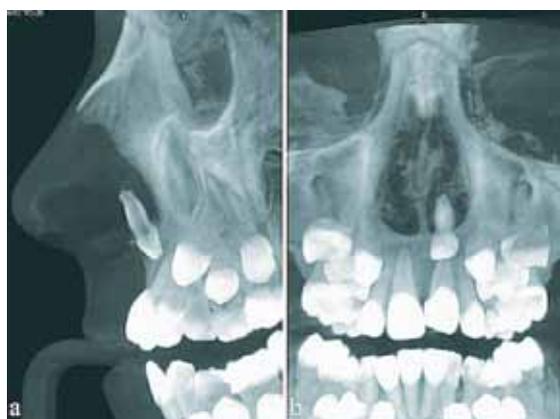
Maximum Intensity Projections (MIP) from CBCT that visualise the position of the deeply intruded primary upper left central incisor in relation to surrounding structures; sagittal view (a) and coronal view (b)
